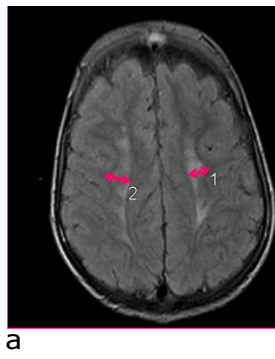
Axial flair MRI. a, Width of the gliosis on the right and on the left; b, distance between the gliosis and the cortex on the right and on the left.
